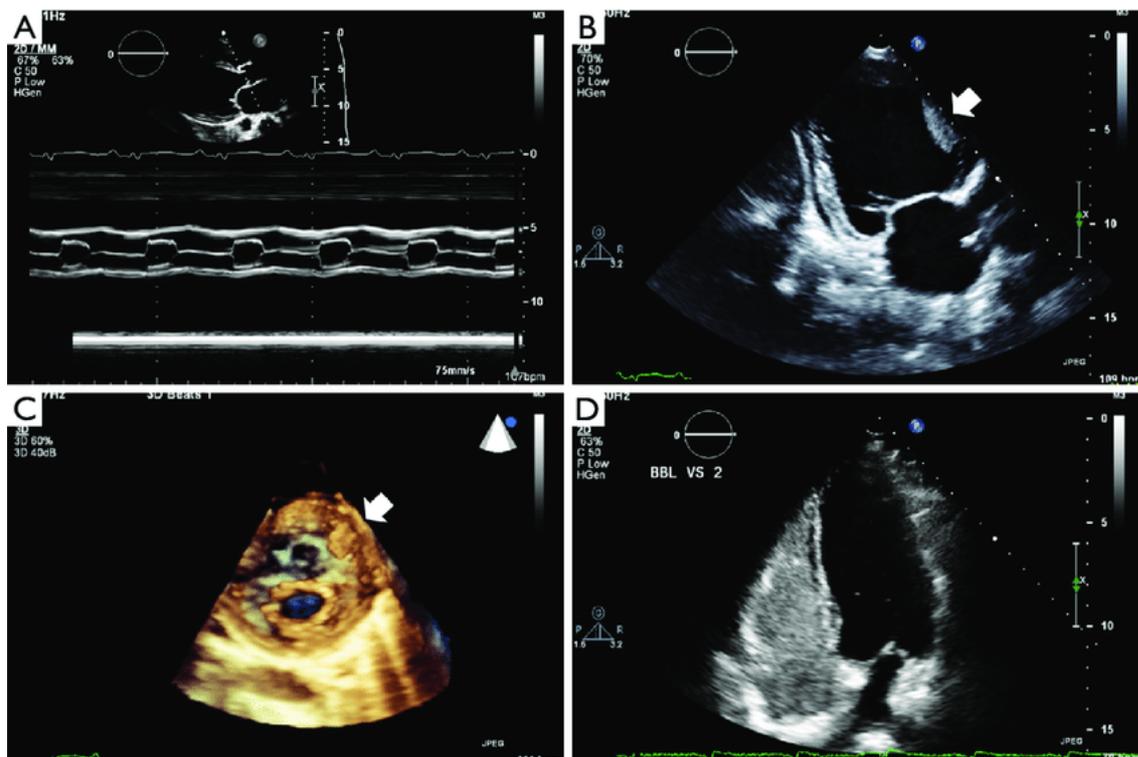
Comparative of different echocardiograph modalities. (A) M-mode imaging of the left atrium and aortic valve. (B) 2D imaging of the left ventricle with mass adherent to anterior wall. (C) 3D view of the left ventricle with mass adherent to anterior wall. (D) 2D contrast echocardiography of the right ventricle (Di Franco *et al.* 2017).
